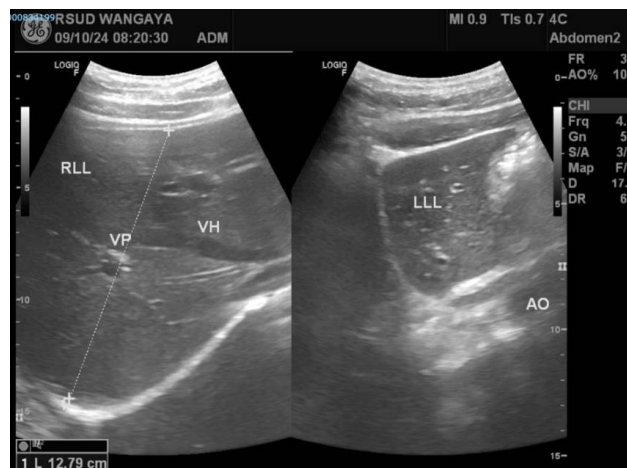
Ultrasonography of the patient's liver
